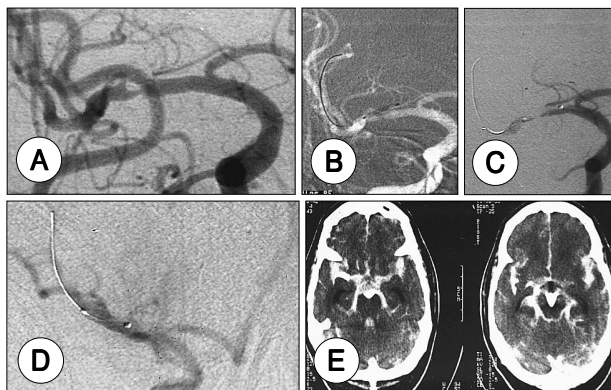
Arterial rupture during stenting with GFX 3.5- \times 9.5-mm stent for the right M1 stenosis. A : Initial angiogram shows a high-grade(90%), eccentric, focal(length<5mm), atherosclerotic stenosis of the M1 segment. B : A 0.014-inch microguide wire is advanced to the stenosis of the right M1 segment, crossed the lesion, and is introduced to the level of inferior division of the right middle cerebral artery to ensure maximal support. C : Angiogram confirms its intraluminal position. D : Angiogram obtained immediately after dilatation reveals a rupture of the right M1 segment, manifested by acute extravasation of contrast material. E : CT scan demonstrates massive subarachnoid hemorrhage with diffuse distribution of contrast material.
